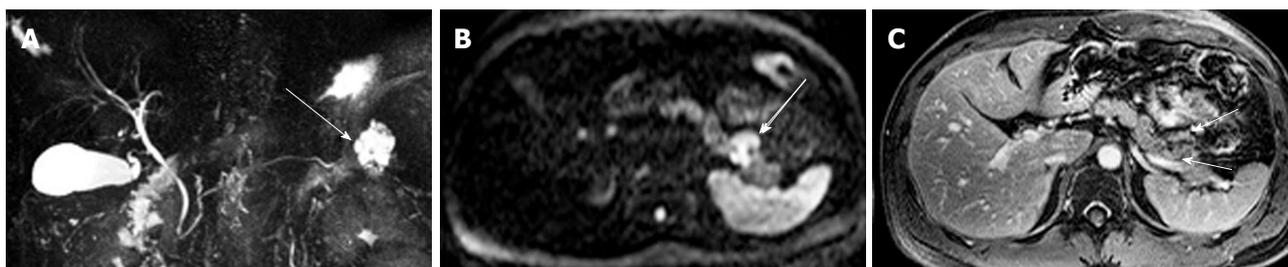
A 39-year-old male with solid pseudopapillary neoplasm. A: Magnetic resonance cholangiopancreatography shows a high intensity pancreatic tail mass (arrow) that appears as a cluster of microcysts, mimicking microcystic serous cystic neoplasm (SCN); B: Axial diffusion-weighted magnetic resonance (MR) image (b-factor = 1000) shows the mass to be high intensity (arrow), unlikely for microcystic SCN; C: The equilibrium phase of an axial contrast enhanced T1-weighted gradient-echo MR image shows peripheral solid enhancing component within the tumor (arrows).
